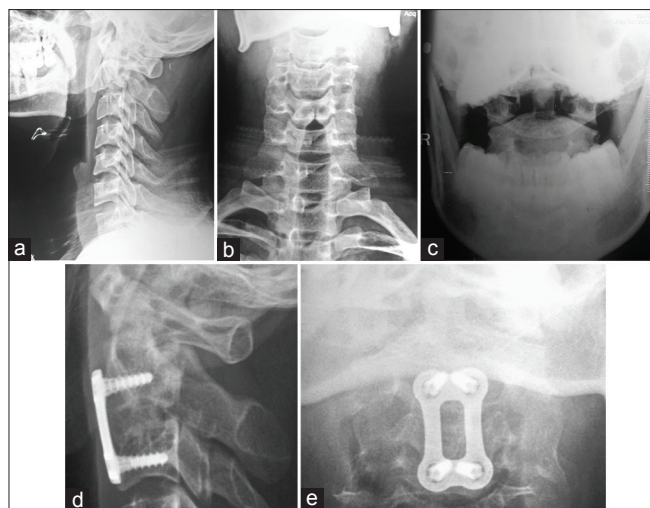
(a-c) Preoperative X-rays of Hangman's fracture (Levine and Edward classification with Starlz and Eismont modification Type IA). (d and e) Six month follow up showing fusion (Bridwell fusion Grade 1)
